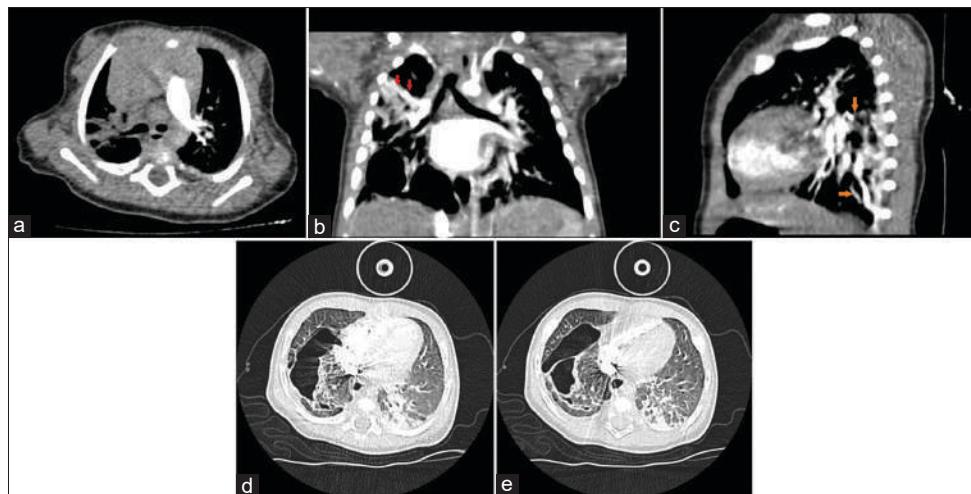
(a) Computed tomography (CT) angiogram showing the absence of the right pulmonary artery. (b) CT angiogram showing collaterals arising from the right subclavian artery and (c) intercostal arteries. (d and e) Contrast-enhanced CT of lung parenchyma showing a multilobular cystic malformation on the right mid and lower lobe as well as atelectasis of the right upper and lower lobe. The red arrows show the collaterals
